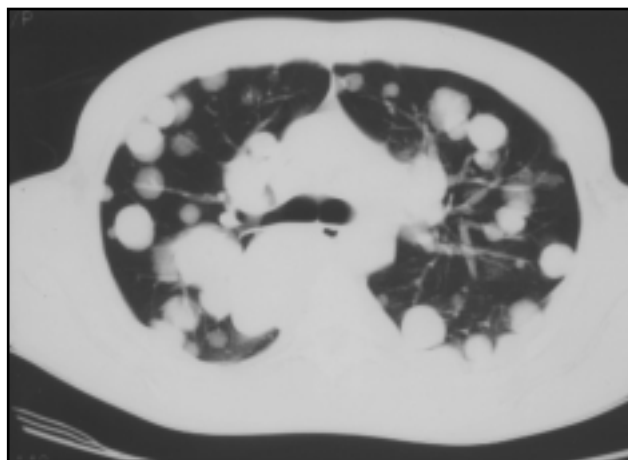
Computed tomography of the chest with multiple nodules representing metastatic disease.
